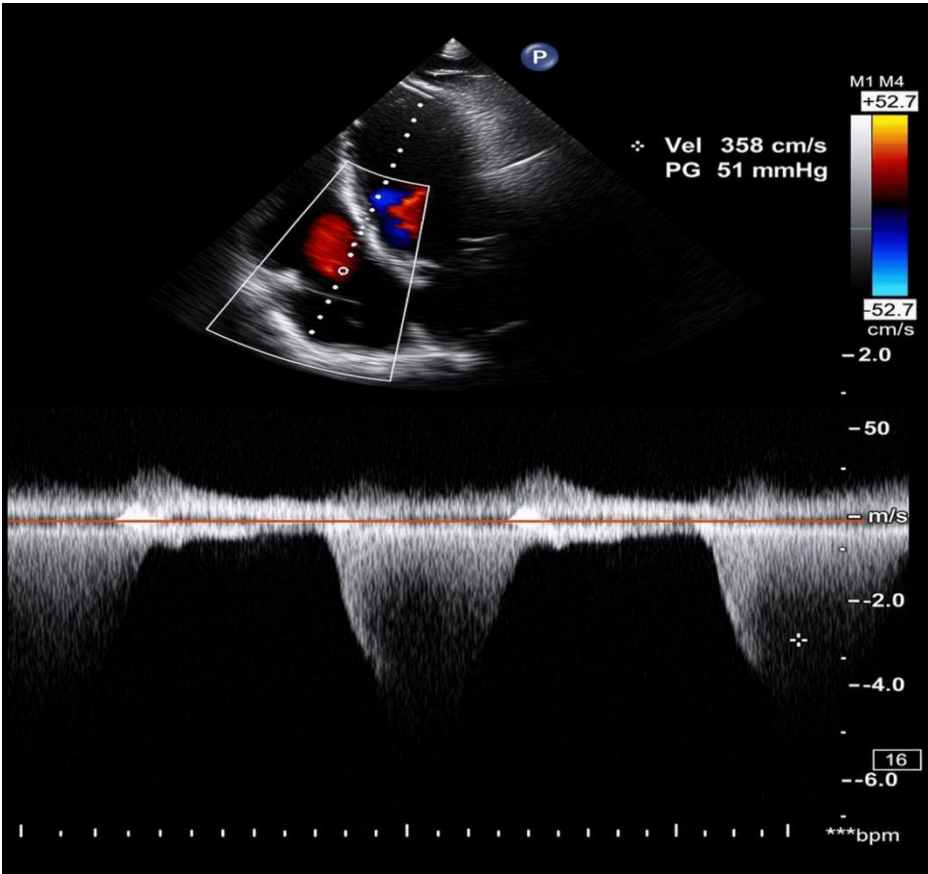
Color-flow and continuous-wave Doppler of the aortic valve.
